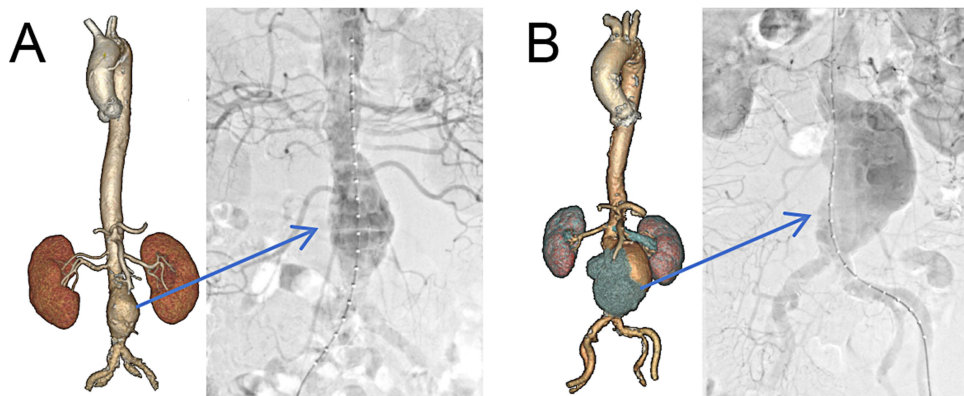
CTA and digital subtraction angiography images (A) unruptured AAA, (B) rAAA.
